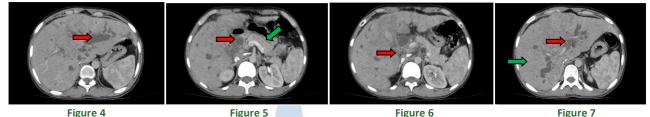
Axial contrast enhanced CT section shows the markedly dilated left hepatic duct and intrahepatic biliary radicals involving left lobe of liver. Figure 5: Contrast enhanced axial CT section shows dilated intrahepatic biliary radicals involving right lobe. Red arrow shows the gall bladder while green arrow shows normal pancreatic duct. Figure 6: Contrast enhanced axial CT section shows mild heterogeneity in the contrast enhancement pattern of liver parenchyma . Red arrow shows dilated CBD (8mm). Figure 7: Axial CECT section shows grossly dilated IHBR involving both lobes of liver shown by red arrow. Green arrow show heterogeneous density of the liver parenchyma
